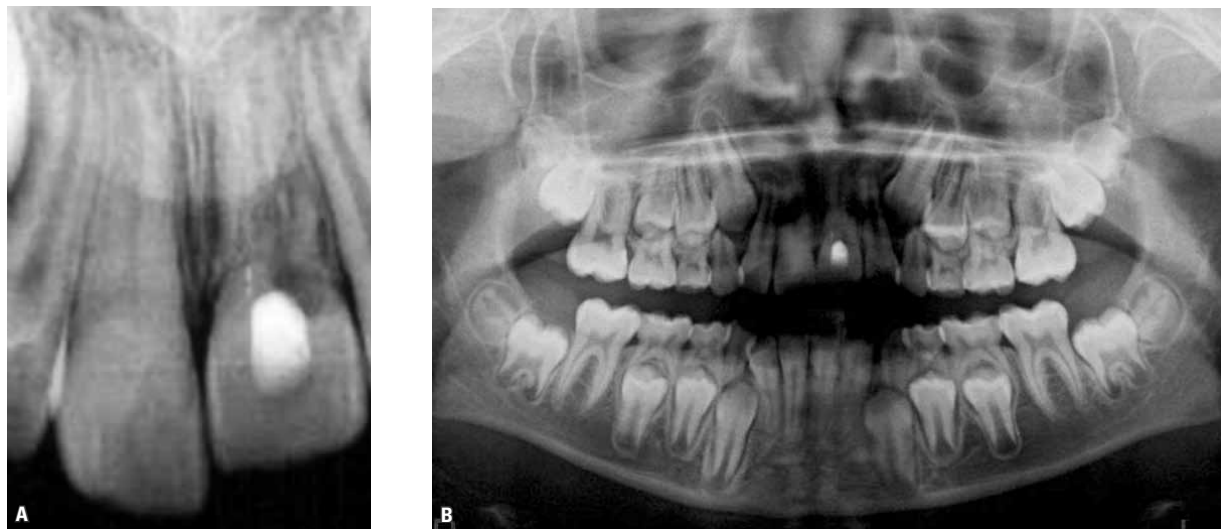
Periapical (A) and panoramic (B) radiographs showing cervical resorption in tooth 21.
